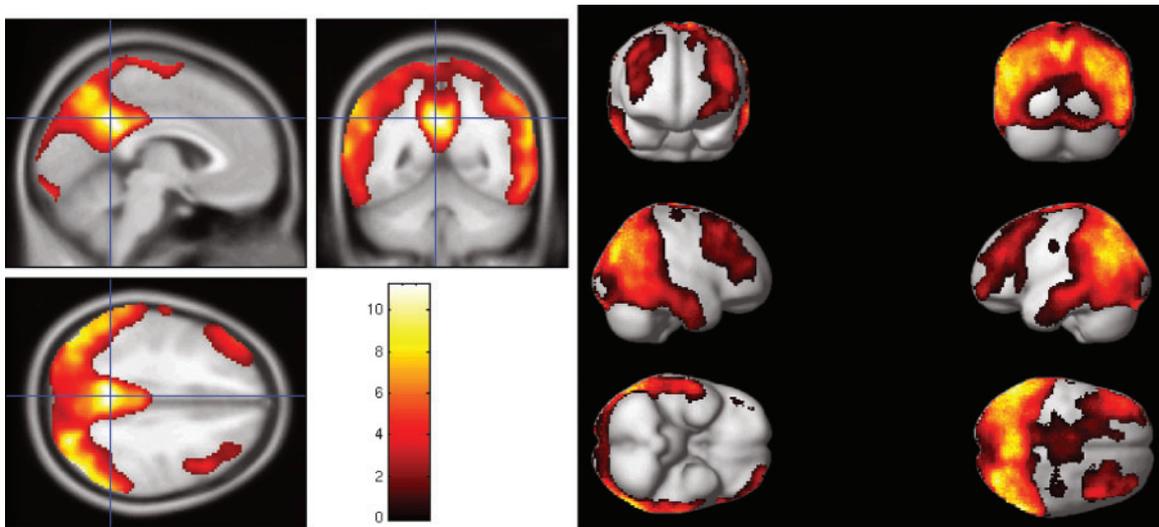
This subject is a 49-year-old woman with severe Alzheimer's dementia who shows statistically significantly abnormal hypoperfusion in parietal and temporal regions on 18FDG PET imaging. The colored scale shows the number of standard deviations from the mean with yellow, indicating the greatest hypoperfusion compared to normal controls
